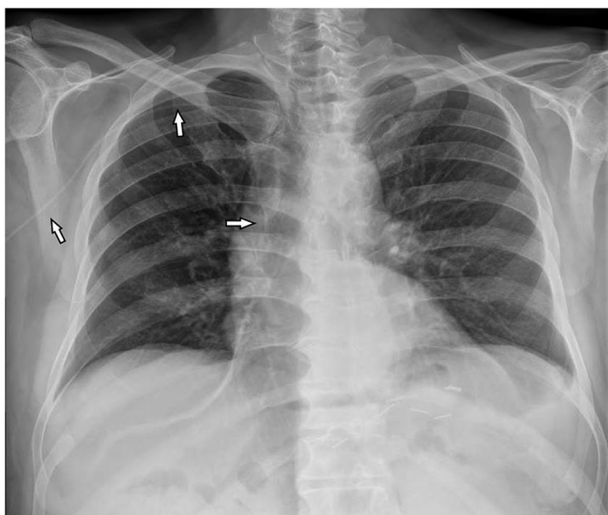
Normal chest X-ray after positioning of a peripherally inserted central catheter line (white arrows) in the right antecubital vein.
